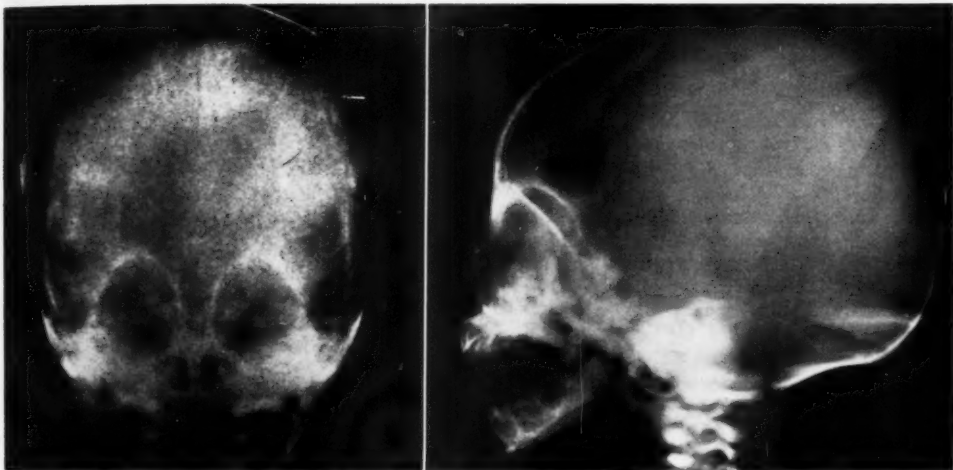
Case II. Roentgenograms of the skull, taken postmortem. Note the smallness of the frontal bone and of the anterior cranial fossa. The orbits are approximated.
